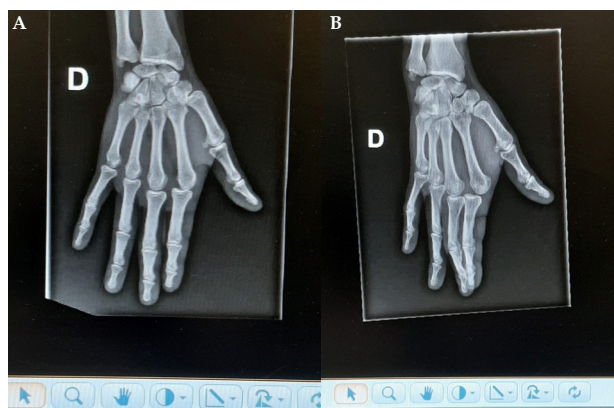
Right hand anteroposterior (A) and lateral (B) radiographs preoperatively demonstrate dorsal dislocation of the index MCP joint.
